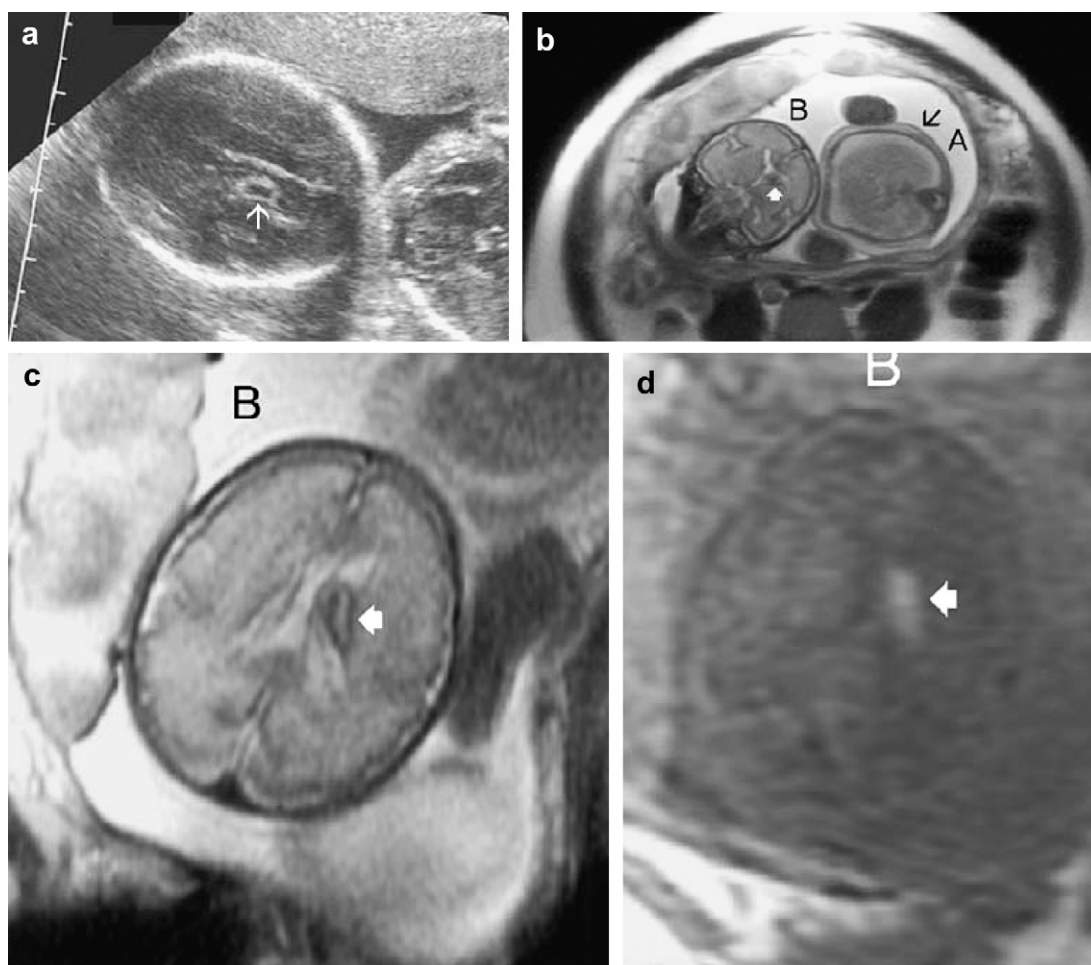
A 23-year-old woman with a monochorionic diamniotic twin pregnancy with a history of co-twin demise at 28 weeks, 5 days. (a) Prenatal ultrasonographic image at 29 weeks taken in axial plane through the head of the surviving twin shows a 'hypoechoic area' in the periventricular region (arrow) suspicious for haemorrhage. (b) T2-weighted coronal image at 29 weeks, 4 days' gestation through the brain of the surviving twin B shows preservation of sulcal spaces and normal intracranial morphology, with an area of decreased signal in the germinal matrix (white arrow) with abdominal hydrops (black arrow) of the adjacent demised twin A. (c) T2-weighted axial image through the brain of twin B shows the area of decreased signal in the periventricular region without intraventricular involvement (arrow). (d) This corresponds to a focus of increased signal (arrow) on a T1-weighted axial image taken at a similar level. These findings confirm an early subacute Grade I haemorrhage. Reproduced with kind permission from Springer Science and Business Media: Hu et al.³⁸
